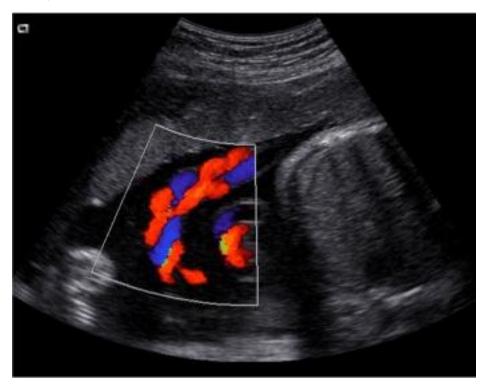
Ultrasound color imaging of umbilical cord arteries and vein. Red: umbilical cord vein; and blue: umbilical cord arteries. (from http://www.medical.siemens.com). Image courtesy of Siemens Healthcare (Elbehery MM, et al 2009).
